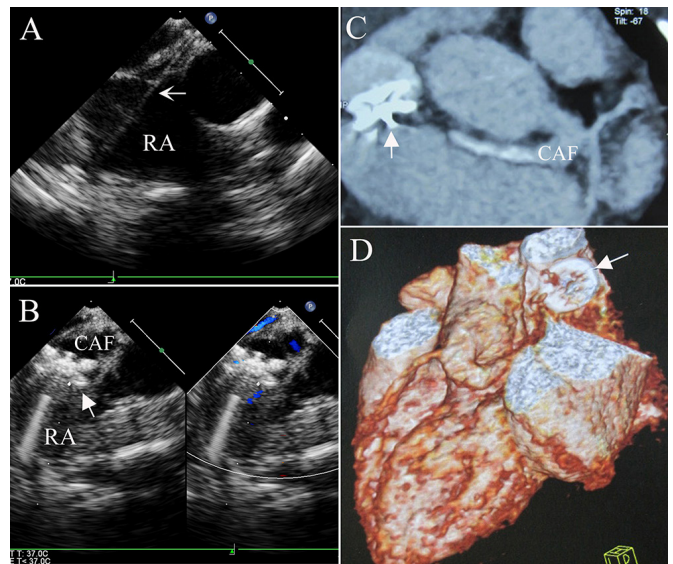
The transesophageal echocardiography (A) showed a flexible guidewire was introduced into the fistulae (arrow), and a symmetric ventricular septal occluder (B) was deployed in place (arrowhead). The follow-up computed tomography scan (C, D) demonstrated the appropriate device position (arrowhead) and the obviously decreased size of the CAF aneurysm (arrowhead). RA indicates right atrium; CAFs, coronary artery fistulas.
